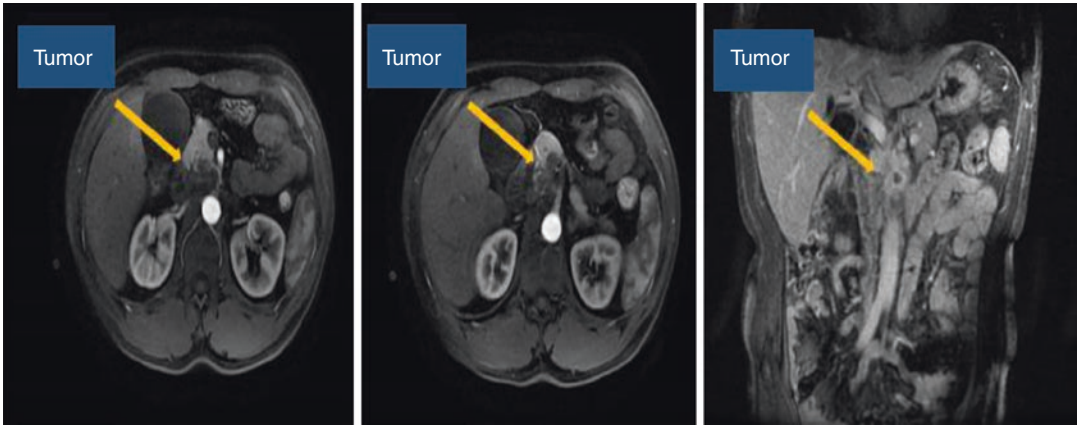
MRI images show a mass in the pancreatic head
